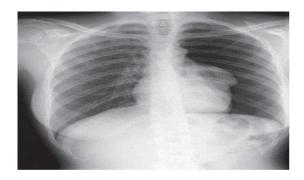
Radiograph showing tumour in the lung (FONG *et al* 2011)
